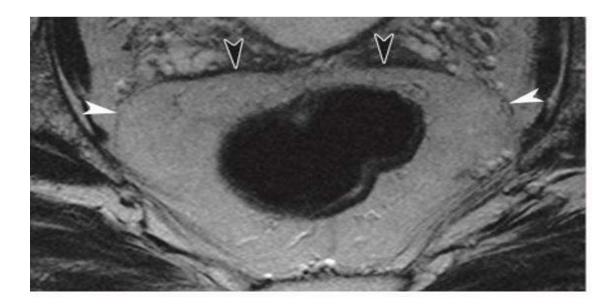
Normal mesorectal anatomy. Axial T2 weighted MR image depicts the mesorectal fascia as a thin, hypointense band (white arrowheads) surrounding hyperintense mesorectal fat. Anteriorly, the fascia appears more thickened and is difficult to differentiate from the Denonviller fascia (black arrowheads)
